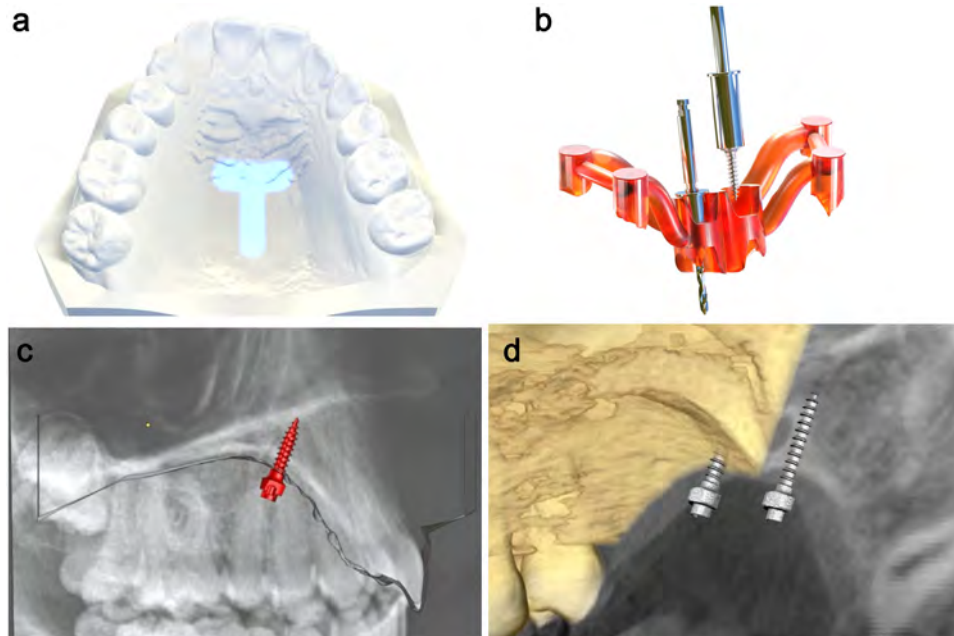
a: the T-zone is the ideal insertion site in the palate. b: digital designed insertion guide for both TAD insertion and pre-drilling (if needed). c: virtual TAD insertion after superimposition of an intraoral scan and a cephalogram. d: virtual TAD insertion after superimposition of an intraoral scan and a CBCT.
